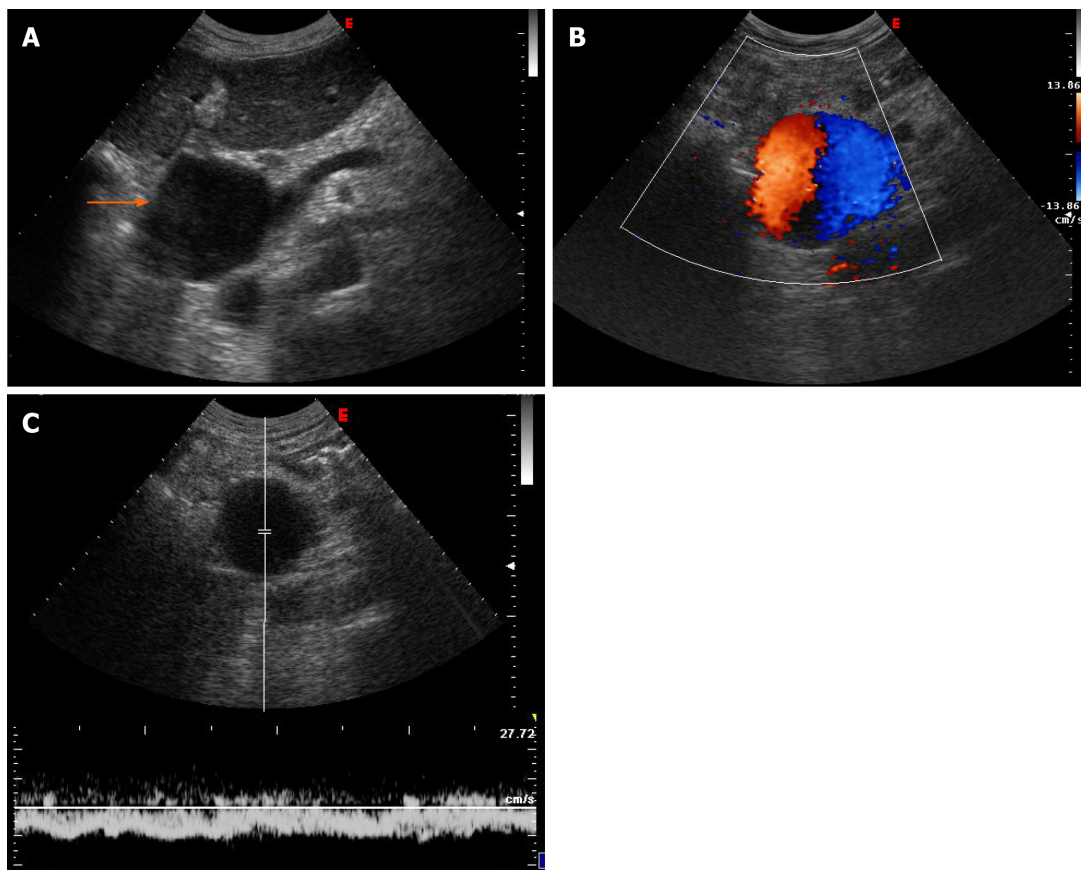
Abdominal ultrasonographic imaging of Case 1. A: Anechoic lesion corresponding to a notably dilated extrahepatic portal vein (arrow); B: Colour Doppler showed the “Korean flag” pathological sign in the dilated portal vein; C: Doppler recording showed flat venous flow.
